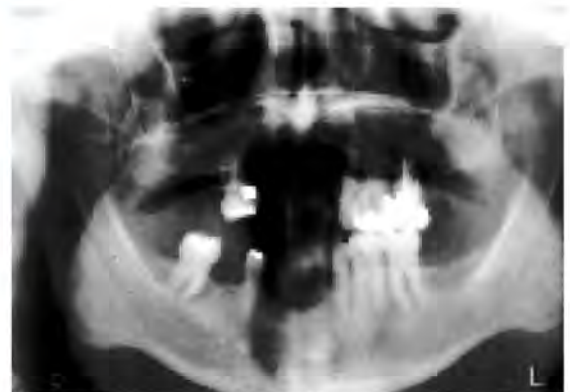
Pretreatment radiograph.
